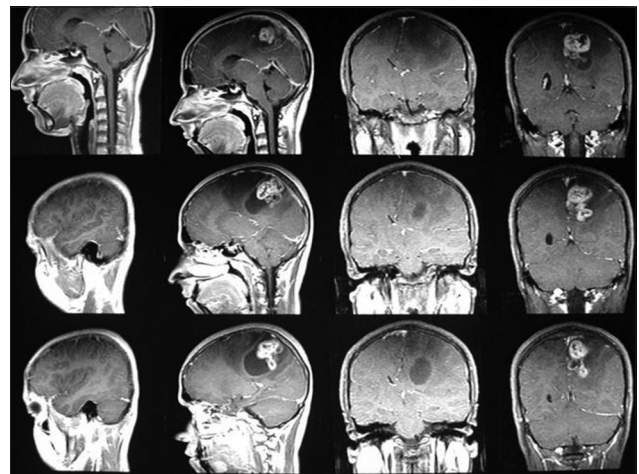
T1 contrast MR images of the patient showing a cyst with enhancing mural nodule in the left parieto-occipital region. Note that there is no communication of the ventricle
